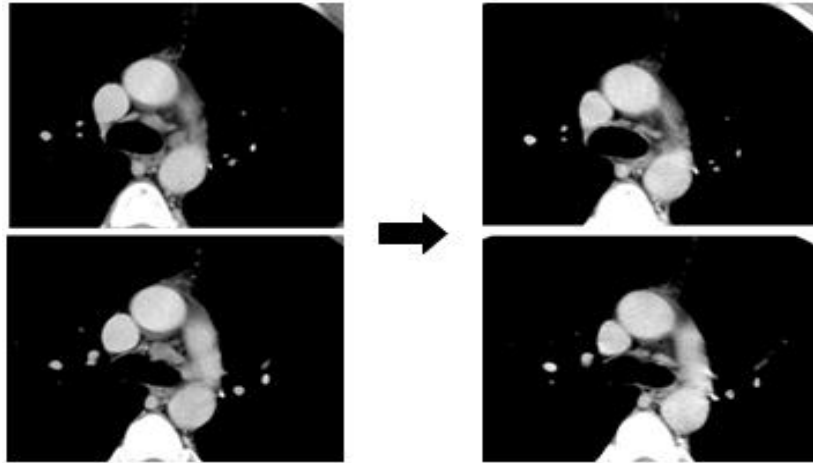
The CT findings of pre- (left) and post- (right) alectinib treatment. Two months after starting alectinib treatment, a remarkable radiological response was achieved.
